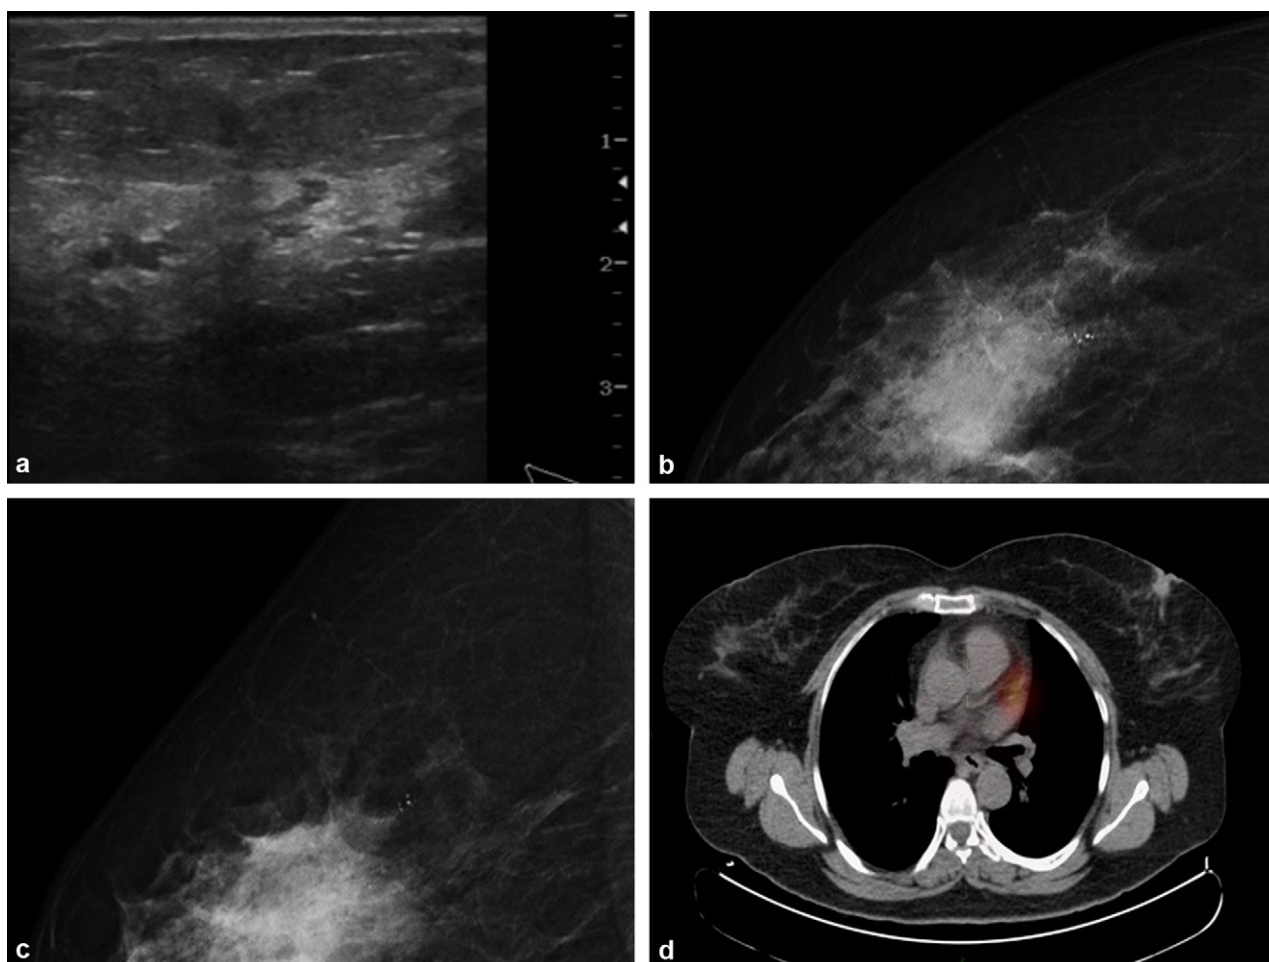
Ultrasound: retroareolar region of the right breast (a), right breast mammogram: enlargement is focused on the external side compartments (b); right breast mammogram: enlargement is focused on the upper compartments in oblique (c) PET-CT performed in the staging (d).
